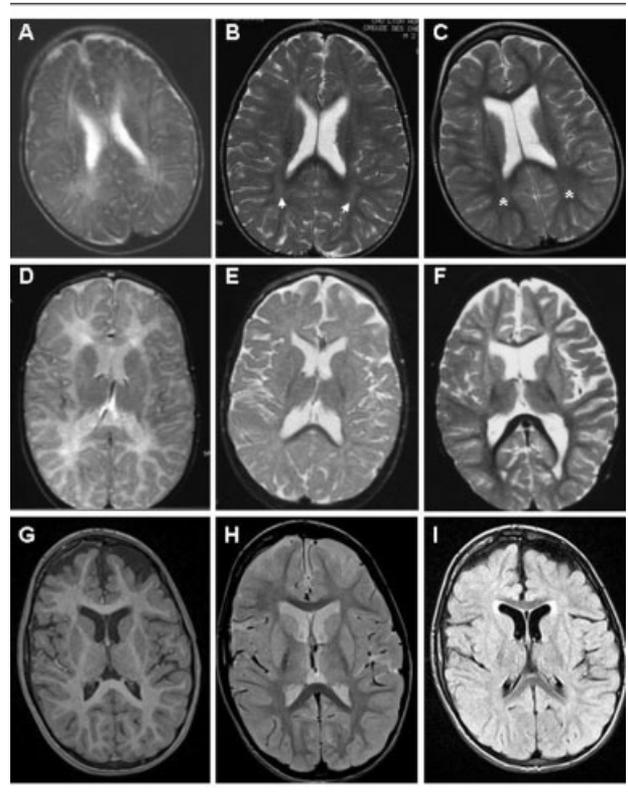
Brain magnetic resonance imaging (MRI) of *MCT8*-mutated patients. (A–C) Follow-up of T2-weighted imaging in Patient 362 at 1 (A), 3 (B), and 5 (C) years of age. MRI demonstrates a progressive improvement of the white matter (WM) signal between 1 and 5 years of age, reflecting a myelination delay rather than a persistent hypomyelination. The corpus callosum appears similarly atrophic at the different ages. (D) T2-weighted imaging demonstrating in Patient 719 at 7 months of age an abnormal diffuse hypersignal of the WM. (E) The abnormal WM signal is restricted to the periventricular regions in Patient 17.2 at 4 years of age. (F) For Patient 17.1, at 10 years of age, the WM is atrophic with a ventricular dilatation but a normal signal. Atrophy of the corpus callosum is clearly present in the three patients (D–F). (G–I) MR images for Patient 664 (T1 [G], T2 [H], and fluid-attenuated inversion recovery [FLAIR] [I]) at 10 years old showing only a mild hypersignal of the periventricular WM on the FLAIR sequence associated with a mild frontal cortical atrophy.
